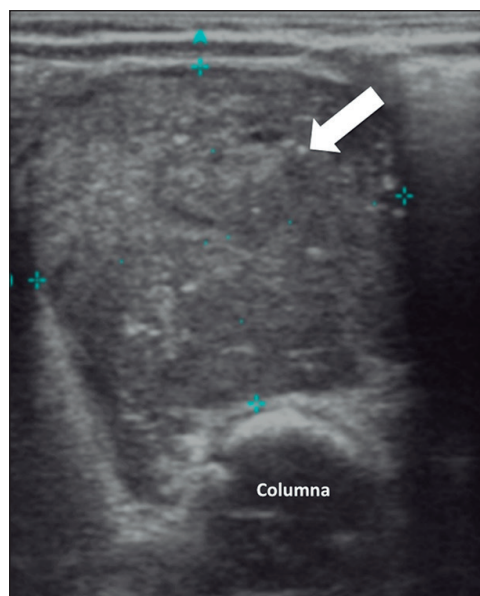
Abdominal ultrasound, transverse section. Large solid retroperitoneal paravertebral mass, discretely lateralized to the right with well-defined borders (arrow). The lesion is solid, slightly heterogeneous with scattered punctate hyperechoic images (calcifications).
